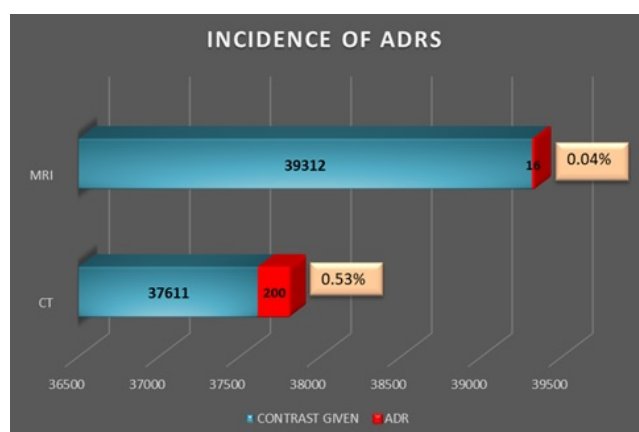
Incidence of ADRs related to contrast agents used in CT and MRI
